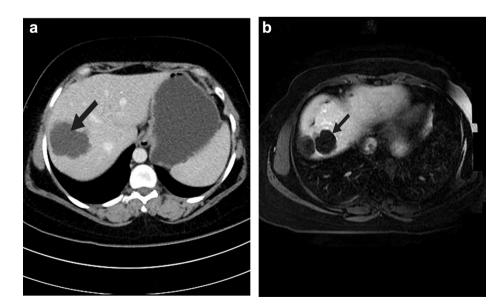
(a) Computed tomography showing a suspicious diagnosis of hepatobiliary cystadenoma confirmed by (b) MRI with internal septations.
